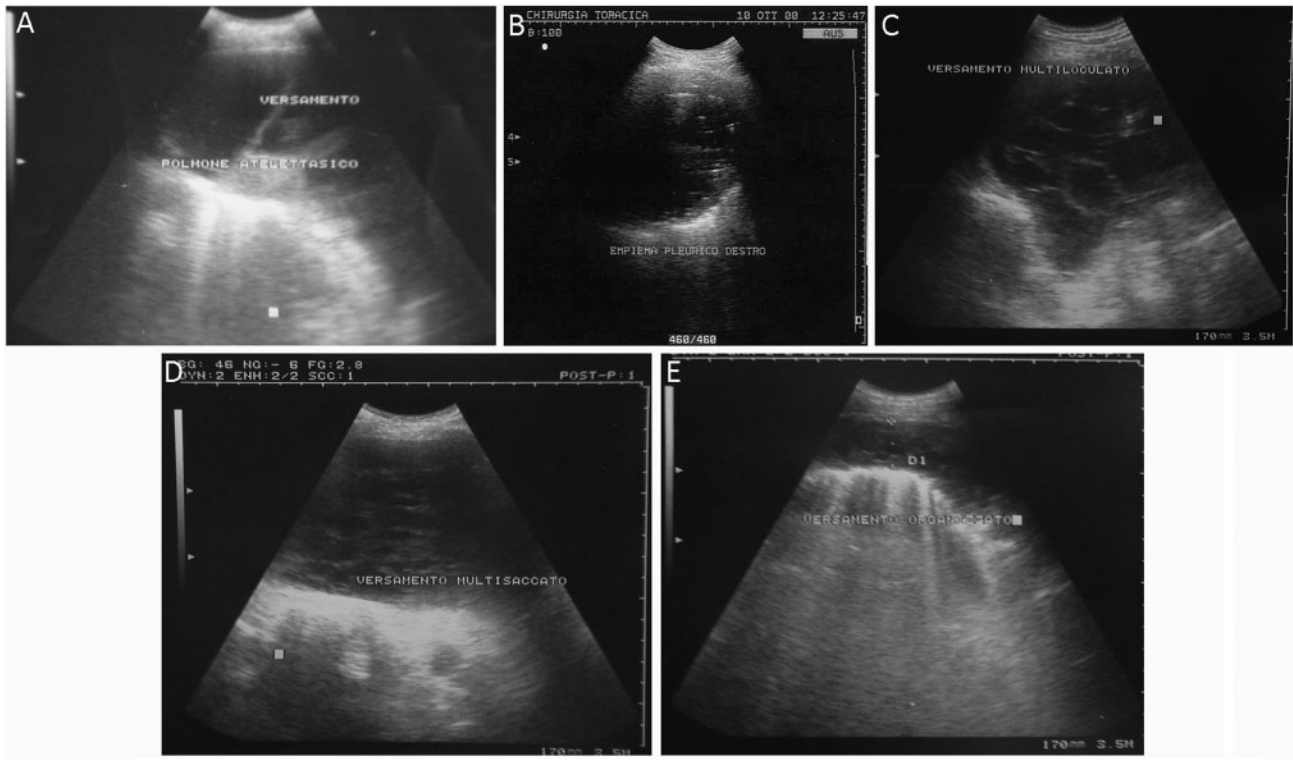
Ultrasonographic patterns of our classification.
